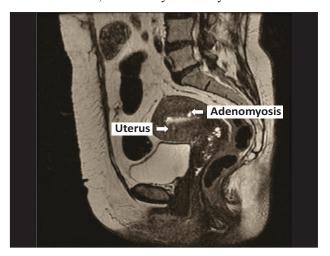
MRI shows weakly defined junctional zone of the endometrium with discontinuous variability of the surrounding myometrium, suggesting adenomyosis.
